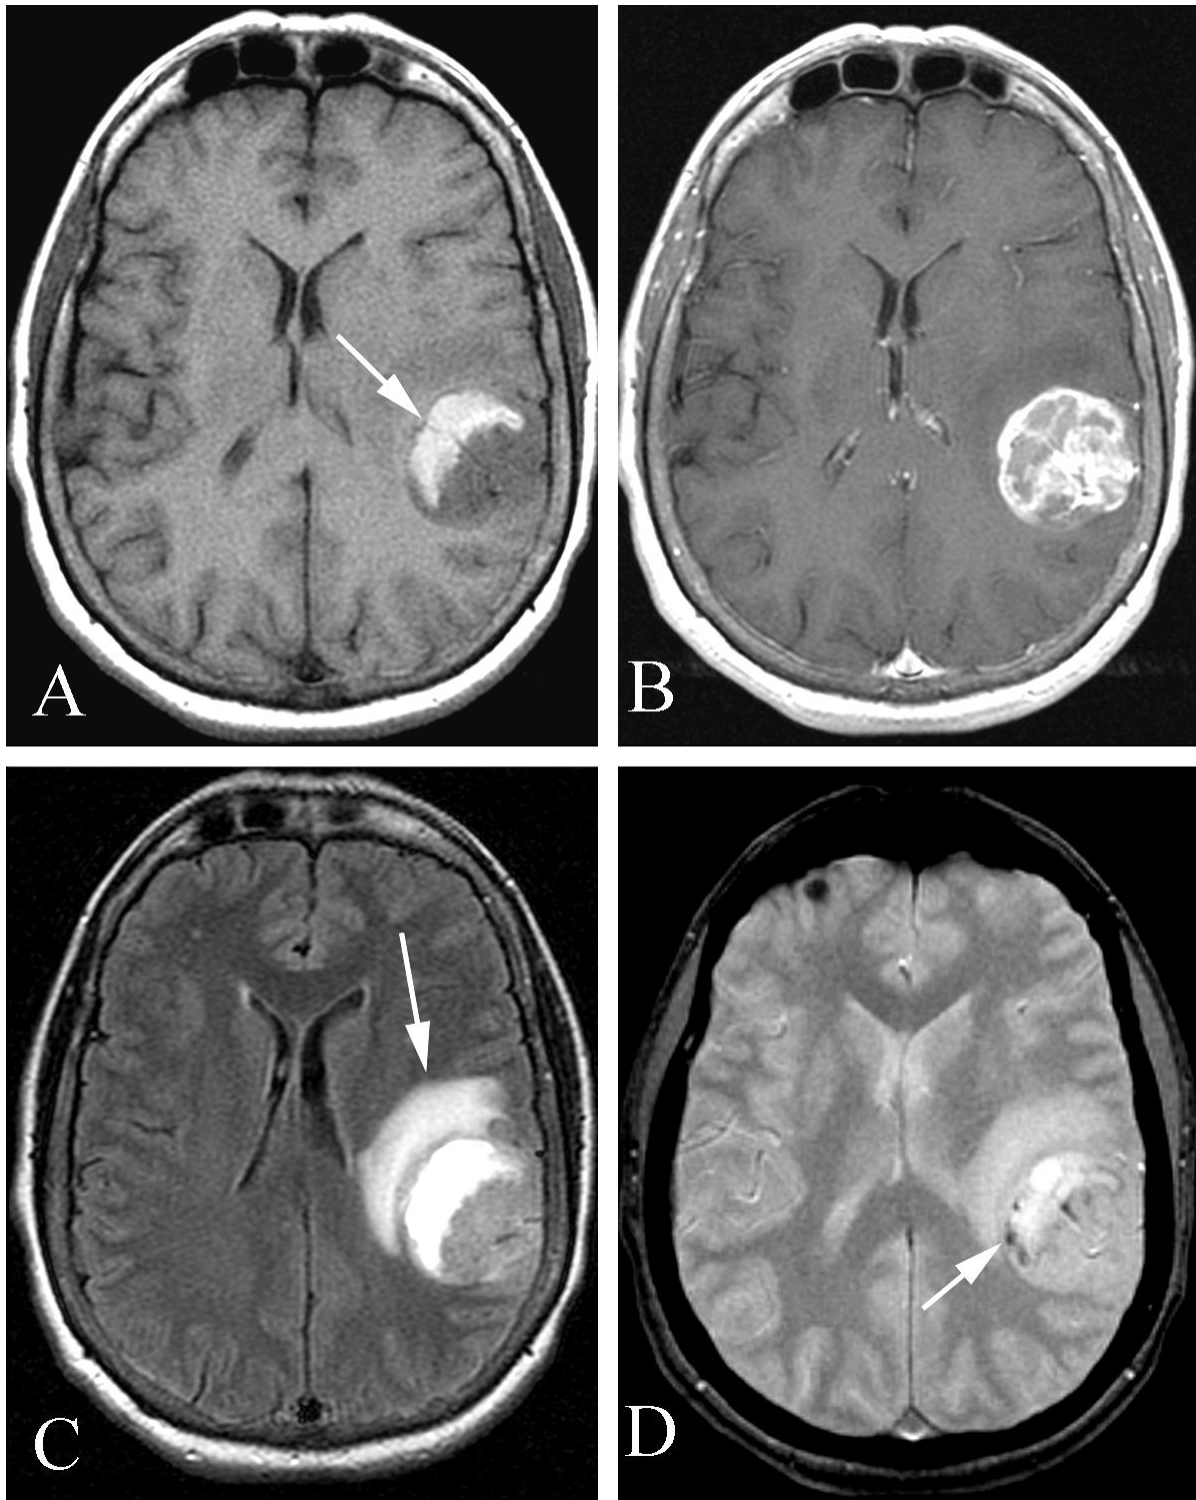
Glioblastoma multiforme in a 57 year old woman with transient verbal difficulty initially thought to be ischemic. A. Axial unenhanced T1 weighted image demonstrates a mass in the left temporal lobe with increased signal intensity along the anteromedial margin compatible with recent hemorrhage (arrow). B. Axial T1 postcontrast image demonstrates intense contrast enhancement of the lesion. C. Axial FLAIR image demonstrates the lesion and marked adjacent white matter vasogenic edema (arrow). D. Axial T2 image demonstrates focal areas of decreased signal intensity (arrow) compatible with intratumoral hemorrhage.
